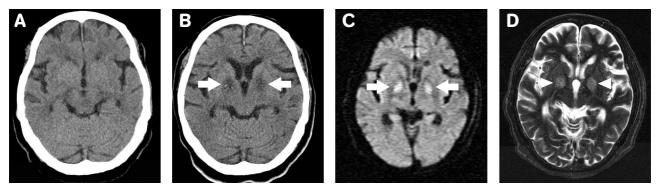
Non-contrast brain CT before correction of hyponatremia was normal (A); compared to the one performed two days later, showing hypodense lesions over bilateral globus pallidus (white arrow) after correction of hyponatremia (B); follow-up non-contrast MRI 1 week later showed increased signal intensity in bilateral globus pallidus on DWI (C: white arrow) and T2WI (D: white arrowhead).
